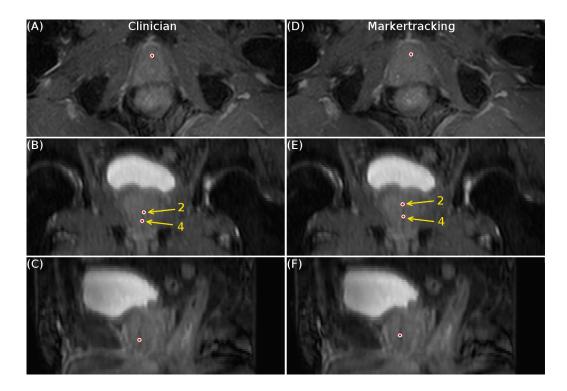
Overview of one cine-MR image set with the largest difference of the COM between the manually segmented markers by the clinician and the positions found by the marker tracking algorithm. Image A-D, B-E and C-F show the respective axial, coronal and sagittal slices of a patient at the end of an imaging session. The marker positions found by the clinician are provided in images A, B and C, while the marker tracking positions are provided in images D, E and F. In this Figure, the middle of the fiducial marker is indicated by the dot, as found by the clinician or marker tracking algorithm. The arrows in image B and E show the position of markers number 2 and 4. The marker shown in image A, D, C and F is labeled with number 4, corresponding to Figure 10.
